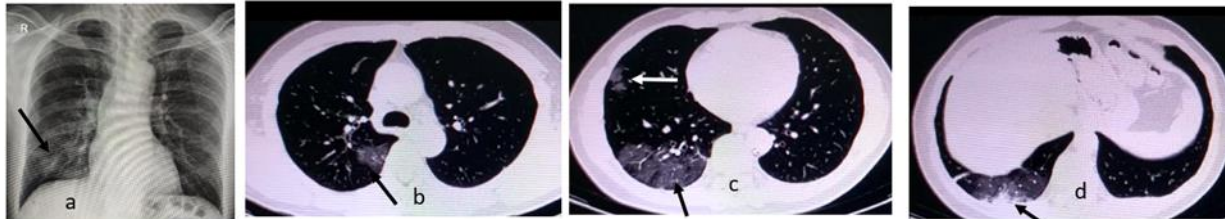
(Case 2) CXR shows GGO in the right lower lung zone suitable to atypical pneumonia (a). HRCT in the same day shows multifocal subpleural GGO (b c), subpleural consolidation and fibrosis in the right superior and lower lung lobe (d) suitable to moderate typical COVID-19 progressive stage
